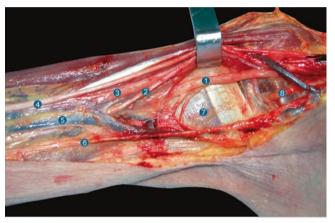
Section of the proximal aspect of the arm with materialisation of the ultrasound beam for axillary block
